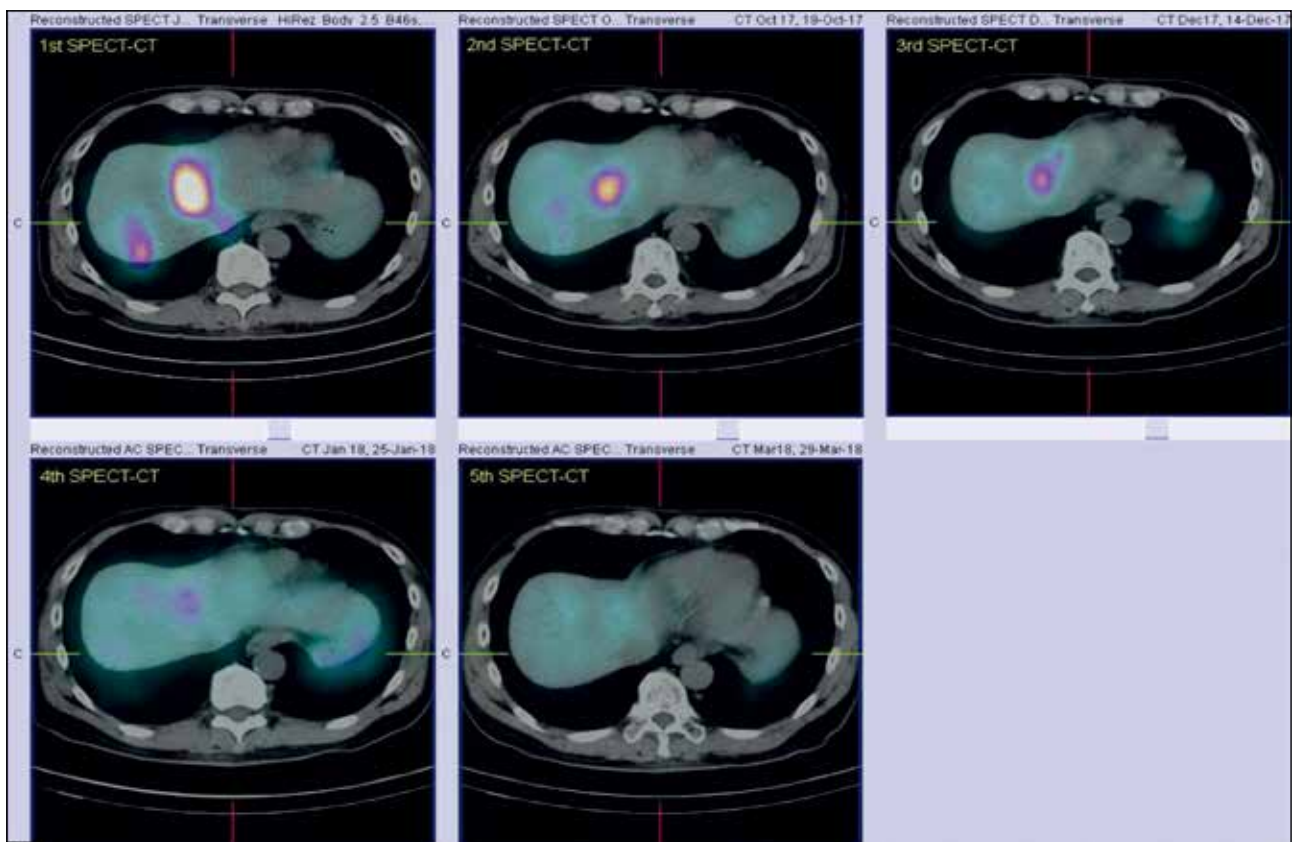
Serial axial single-photon emission computed tomography/computed tomography images in the same 57-year-old man from left upper corner to right lower corner showing an index lesion at the dome of the hepatic lobe at different post-therapy scans. There is an interval decrease in size and uptake intensity of the lesion.
